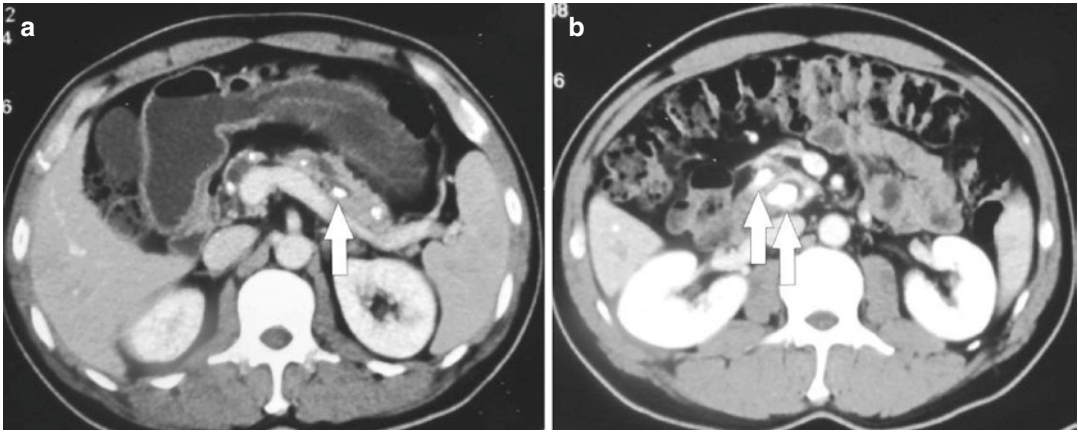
(a) CT revealed marked dilatation of the pancreatic duct with irregular changes in caliber, and a patchy high-density shadow in the pancreatic tail (*arrow*). (b)
